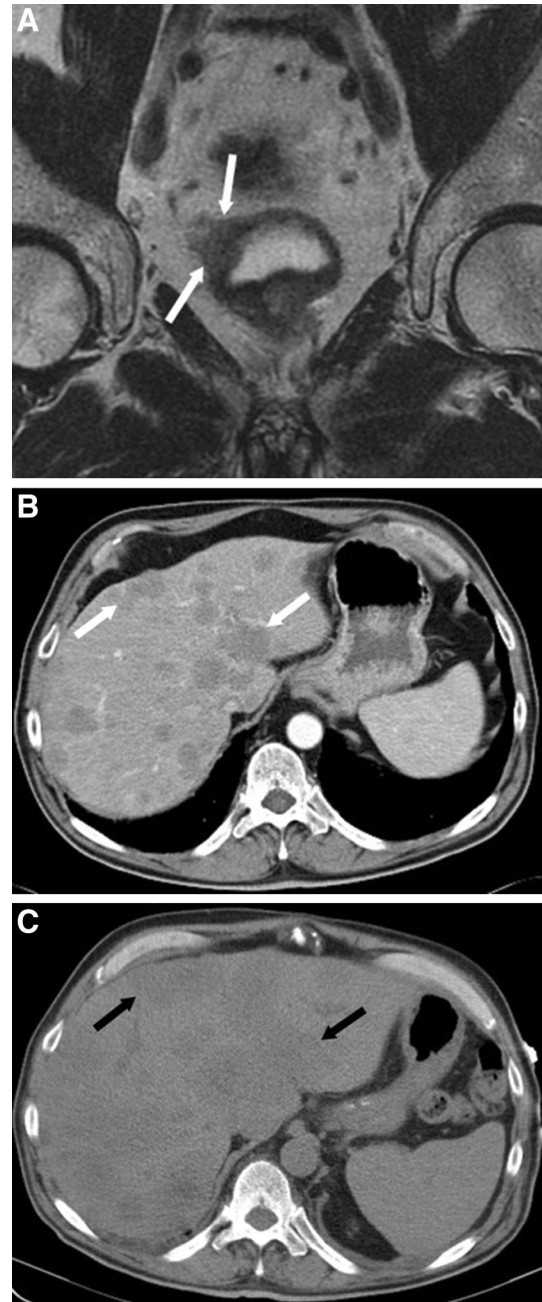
72-year-old male with small cell carcinoma of the bladder, aggressively metastatic to the liver (cT3b stage). A Coronal T2-weighted MRI at diagnosis shows irregular right lateral bladder wall thickening (*white arrows A*) with ill-defined extension into the perivesical fat, in keeping with muscle-invasive bladder cancer. No nodal or distant metastatic disease was found at diagnosis. B 3-month follow-up axial contrast-enhanced CT shows innumerable low attenuating hepatic lesions (*white arrows B*), consistent with metastases. C Restaging axial non-contrast CT obtained 2 months later due to increasing abdominal pain shows increased size of the entire liver and increased size of the hepatic lesions, indicating worsening of disease.
